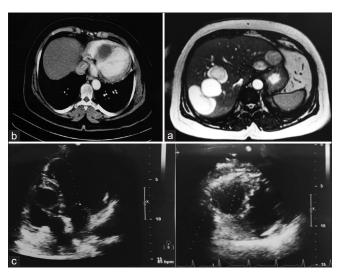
(a) Computed tomography of abdominal showing multiple hydatid cysts in the liver. (b) Computed tomography of chest showing hydatid cyst located in the interventricular septum. (c) Echocardiographic showing a large cystic mass splitting the interventricular septum
